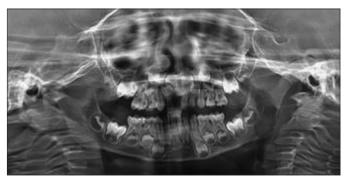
Orthopantomogram image of teeth with normal enamel, dentin and bony patterns.
